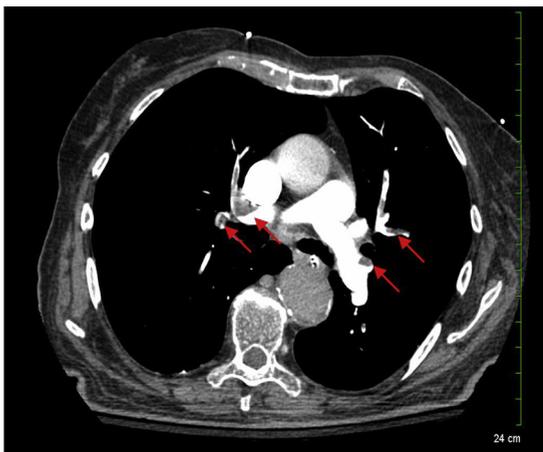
CT scan shows multiple pulmonary emboli (arrows).
